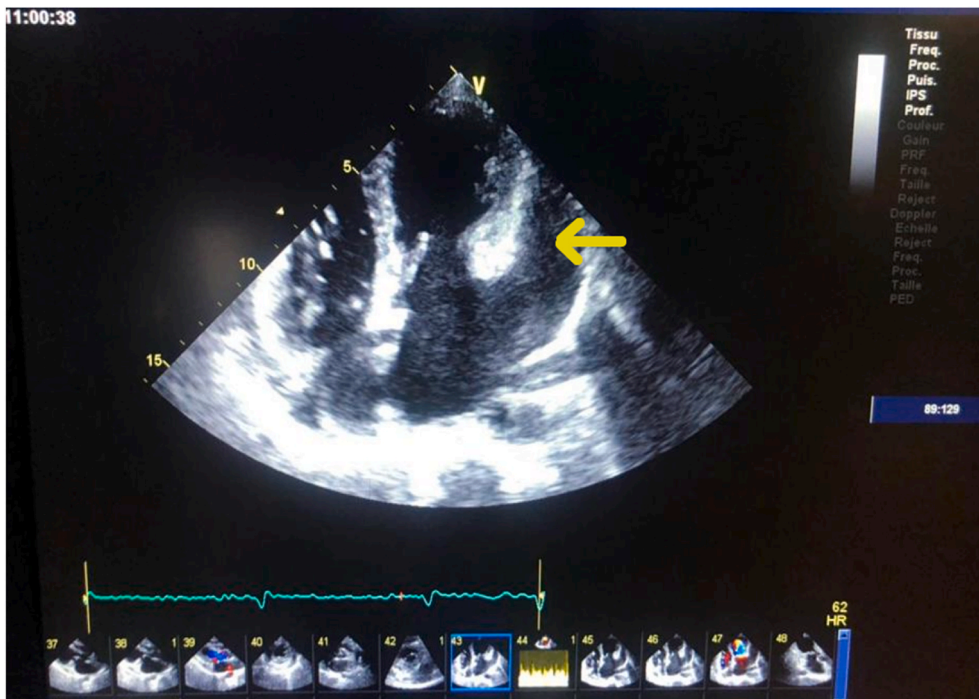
Apical four chamber view in transthoracique echocardiography showed a left atrial appendage aneurysm.
